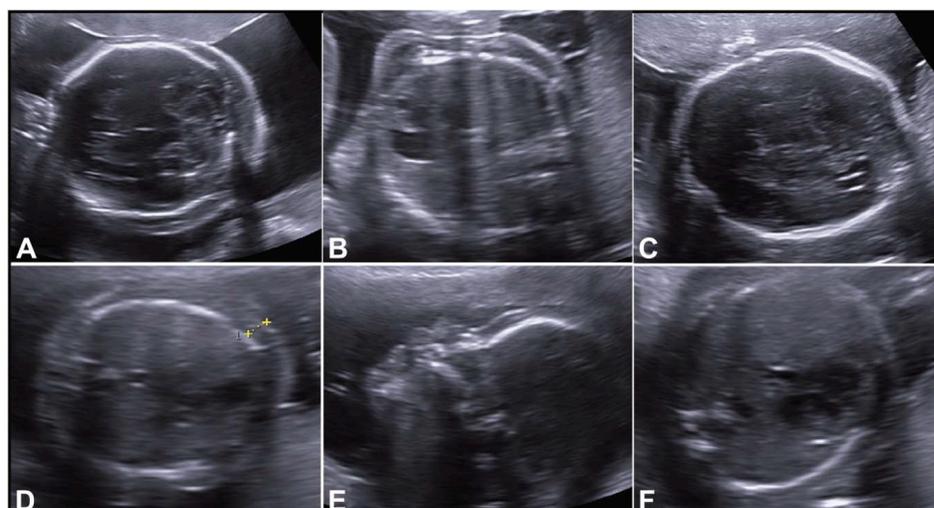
Fetal skin edemas. Fetal ultrasound examinations. Case 1: skin edema in transcerebellar (A) and transthoracic (B) planes and its resolution (C). Case 2: skin edema in transthoracic (D) and midsagittal face (E) planes and its resolution (F).
